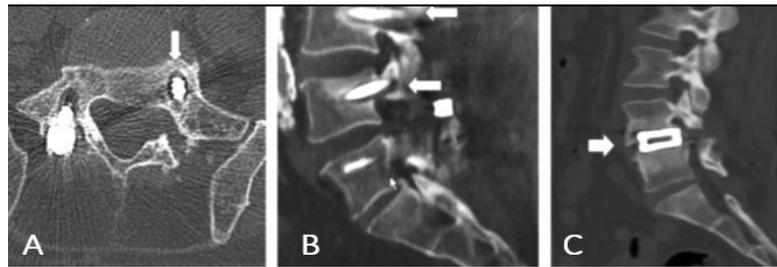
(A) Axial CT scan and (B) sagittal reconstruction showing bone destruction around pedicle screws (indicated by arrows), characteristic of pseudarthrosis; (C) sagittal CT image demonstrating implant subsidence. (Image from the author's personal archive)
